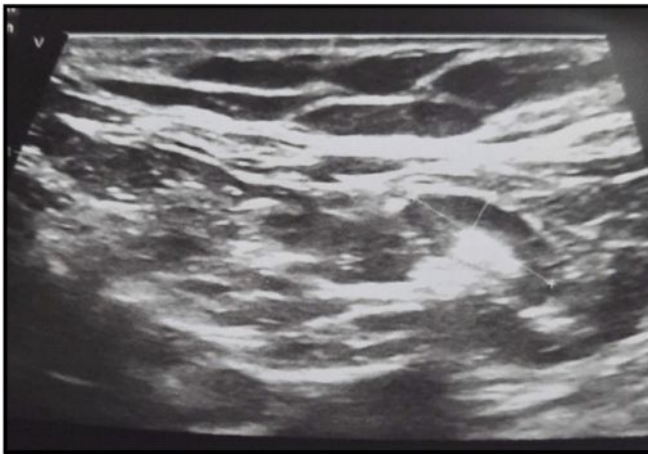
Ultrasonography image showing an ill-defined hypoechoic area (dotted white line)
